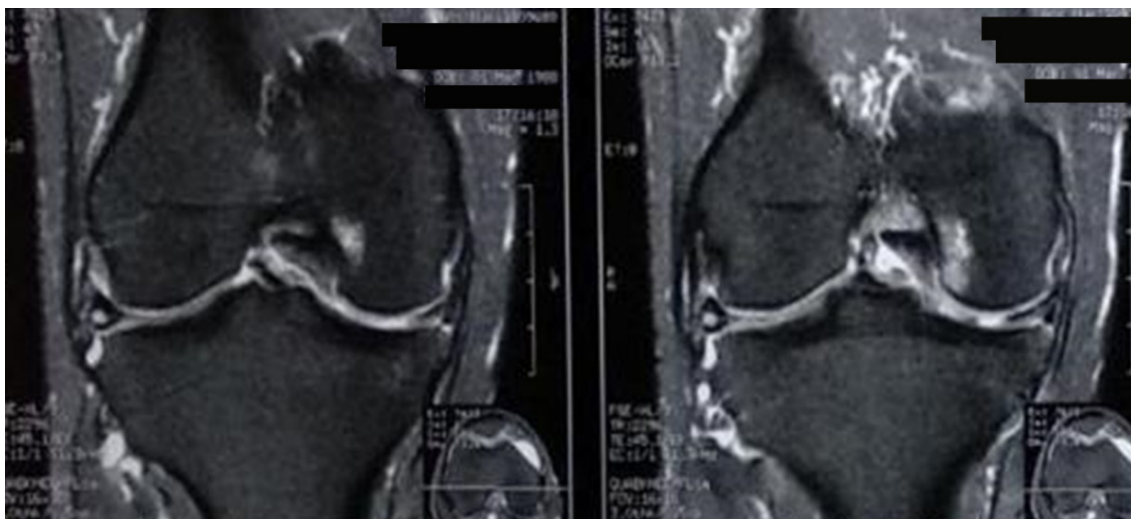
Coronal MRI image of a knee with chronic ACL rupture, revealing non-visualization of the ACL fiber and positive empty wall sign.
